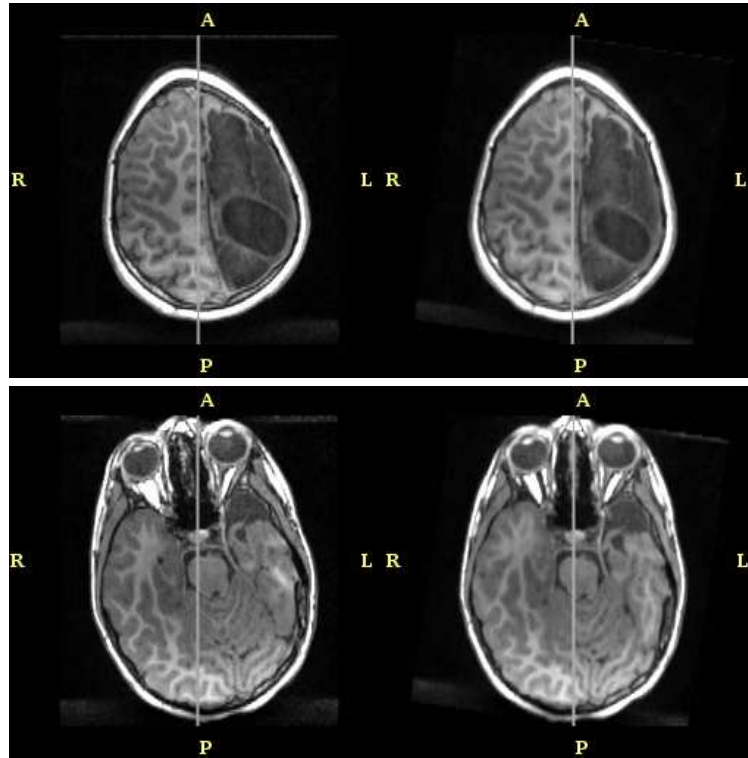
Plane of Symmetry Robustness Test Results - Axial View. The left image of every pair shows the original T1-weighted MRI while the right image shows the volume aligned to the plane of symmetry. The gray line represents the plane of symmetry in the slice shown.
